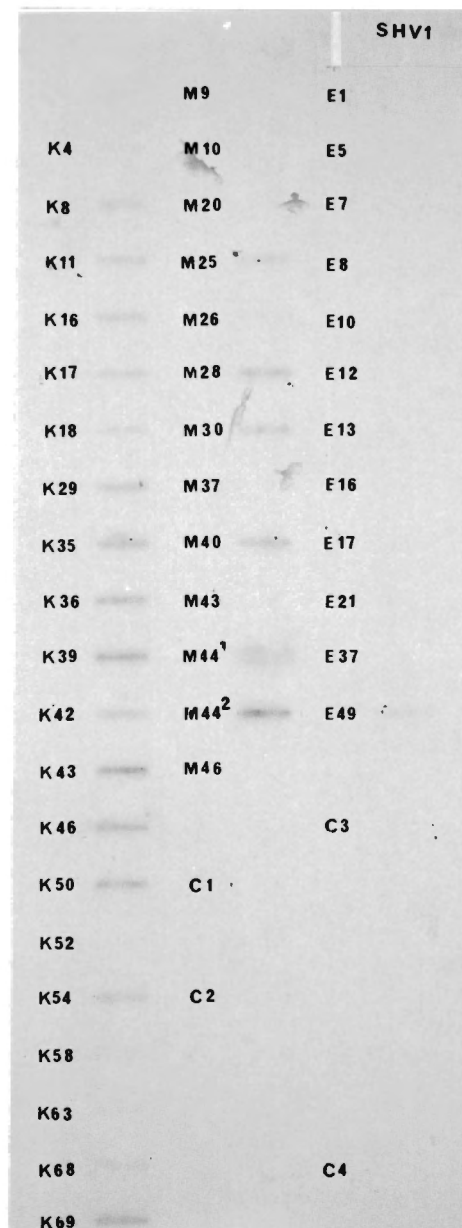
ii Hybridisation of SHV oligoprobe ($[^{32}\text{P}]$ labelled) to genomic DNA of isolates. Overnight exposure to X-ray film (Hyperfilm, Amersham). The signals obtained from hybridisation to DNA of isolates K4, K63 and M26 are not readily visible in the photograph, but are discernible (albeit weakly) in the original autoradiograph.
